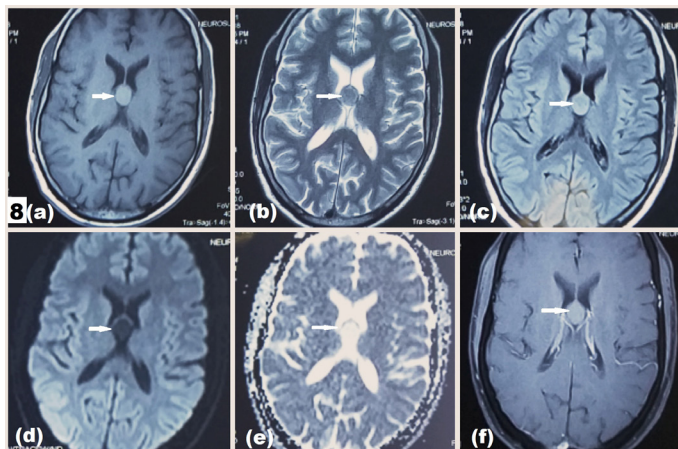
MRI of a 25-year-old male patient with colloid cyst (arrow) in the third ventricle. (a) T1WI axial shows a high-signal-intensity lesion in the third ventricle. (b) On T2WI the lesion appears iso- to hypointense. (c) Flair image of the lesion is isointense to cortex. (d-e) The lesions show no obvious restriction on diffusion and ADC map. (f) The lesion shows no enhancement post contrast.
